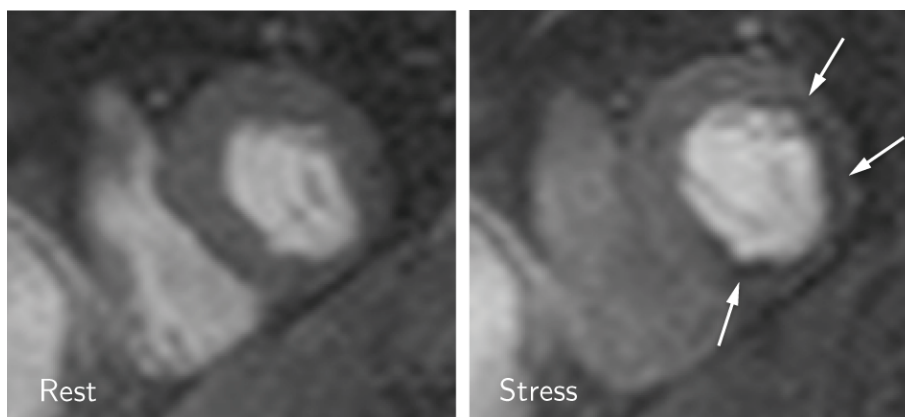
First-Pass Perfusion Cardiac Magnetic Resonance images in short-axis view at rest (left) and at stress (right) in a patient with CAD. While perfusion appears to be normal at rest, stress-induced defects are visible in the antero-lateral, lateral, inferior and infero-septal segments.
